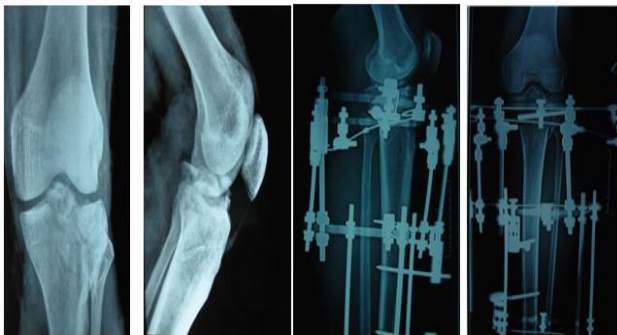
X-rays pre and post-operative.
